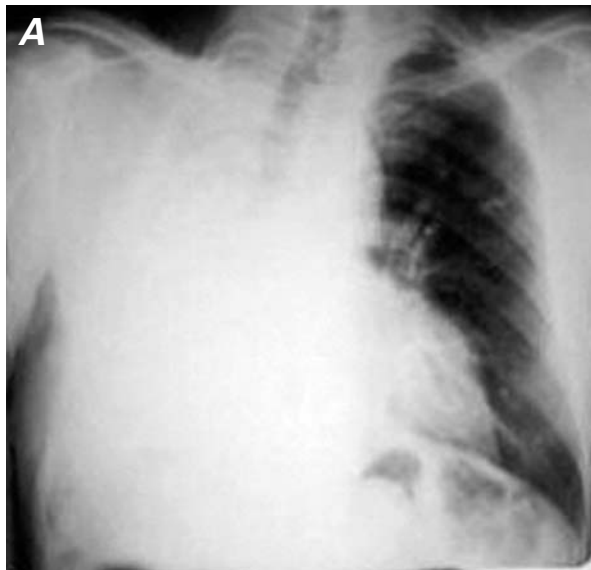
Chest radiography (A) and computed tomographic imaging (B) show a shift of the trachea and mediastinum to the right side, hyperinflation of the left lung, and postpneumonectomy space on the right side.
